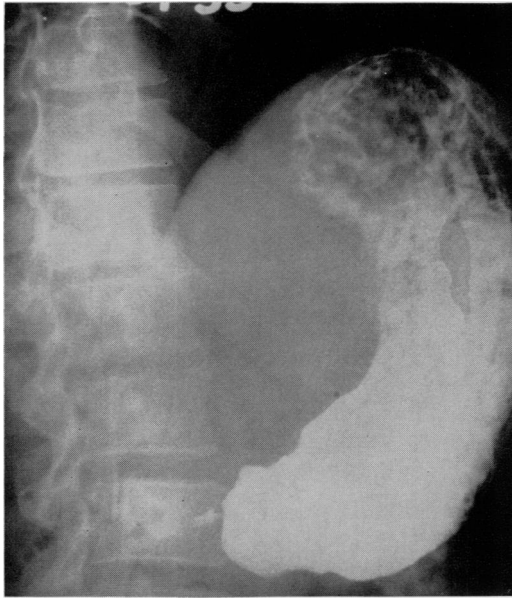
Case 1. The roentgenographic appearance of the barium-filled stomach suggests stenosis due to ulcer, or possibly neoplasm.
